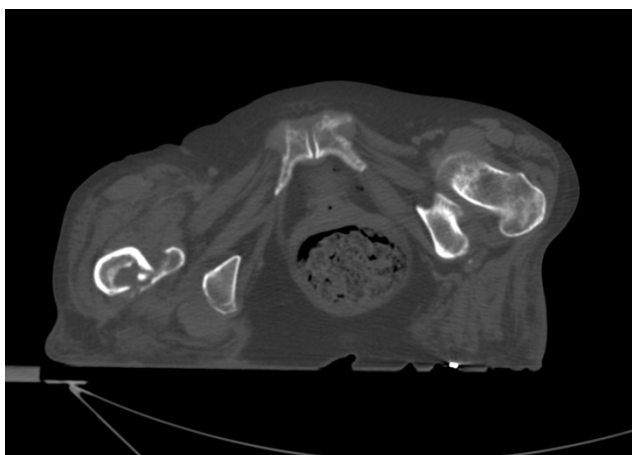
Example of lower extremity/pelvic CT slice used for right femoral artery measurement
